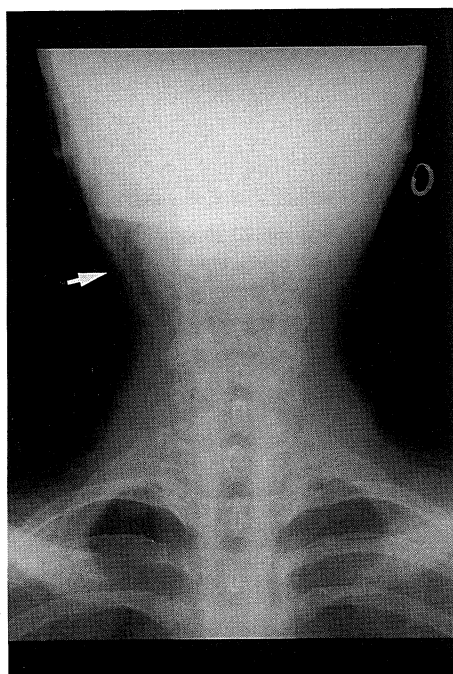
Posteroanterior neck radiograph revealing upper neck emphysema of the right side.
